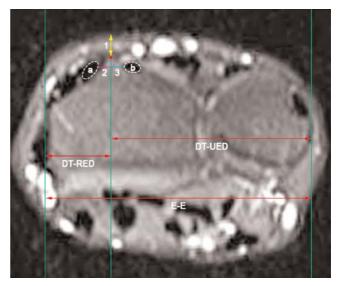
Landmarks used for measurements on an axial wrist MRI. 1: measurement of soft tissue thickness over the tip of the dorsal tubercle; 2: measurement of the horizontal distance between the tip of the dorsal tubercle and the closest tendon on the radial side; 3: measurement of the horizontal distance between the tip of the dorsal tubercle and the closest tendon on the radial side; 3: measurement of the horizontal distance between the tip of the dorsal tubercle and the closest tendon on the and ulnar side, a: extensor carpi radialis brevis tendon; b: extensor pollicis longus tendon; red dot: tip of the dorsal tubercle and the radial bony edge; DT-UED: the horizontal distance between the tip of the dorsal tubercle and the ulnar bony edge; E-E: edge to edge distance. The green vertical lines were drawn for guidance.
